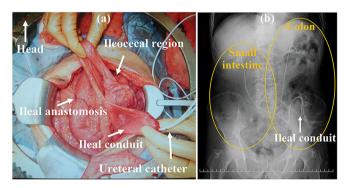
Left side ileal conduit and placement of the small and large intestines. (a) The ileal conduit prepared on the left side after performing the Ladd procedure. (b) A postoperative abdominal radiograph showing the small intestine and large intestine placed in the right and left side, respectively, and the ileal conduit constructed in the left side.
